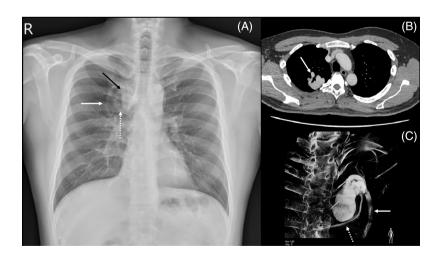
Poster-Anterior view of chest radiography (A) showed a soft tissue density lesion next to the mediastinum (black arrow). A feeding vessel (white arrow) and a drainage vessel (dotted white arrow) can be appreciated by close examination of the soft tissue mass. The axial reconstruction of the contrasted computer tomography (B) revealed the lesion to be a solitary pulmonary arteriovenous malformation (PAVM), with the feeding vessel (white arrow) exceeding 9 millimetres. The selective angiography (C) confirms the feeding vessel (dotted white arrow) originated directly from the right pulmonary artery and drained to the left atrium (white arrow).
